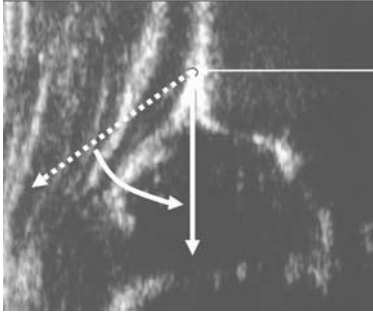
Typical “high” sharp osseous rim, which is the sonographic expression of physiological ossification in type II hips. *Two arrows* mark the osseous rim; a *circle* marks the turning point
